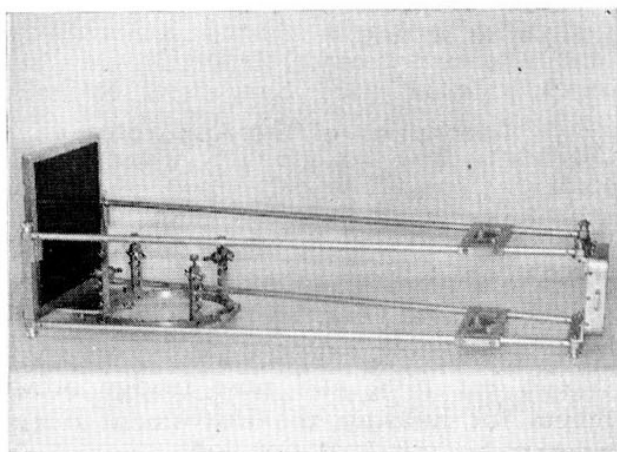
X-ray alignment frame 100 cm. in length shown attached to subframe.
